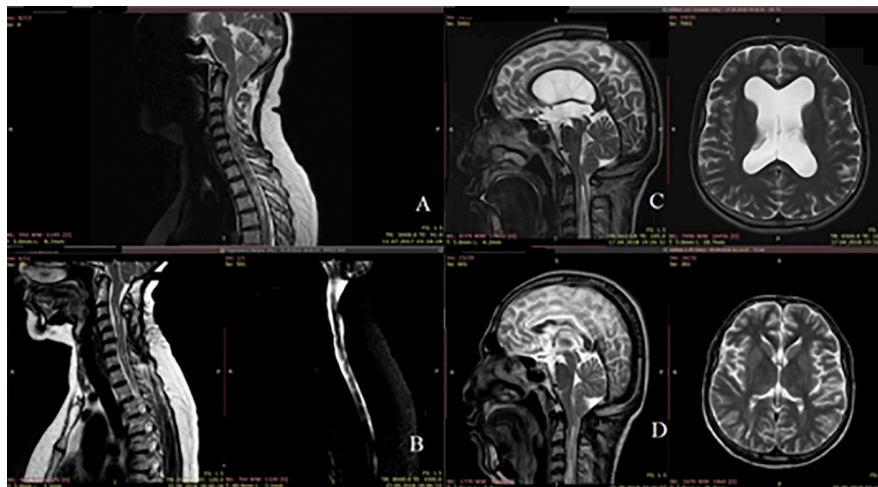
Brain and cervical spine MRI, T2 mode.
